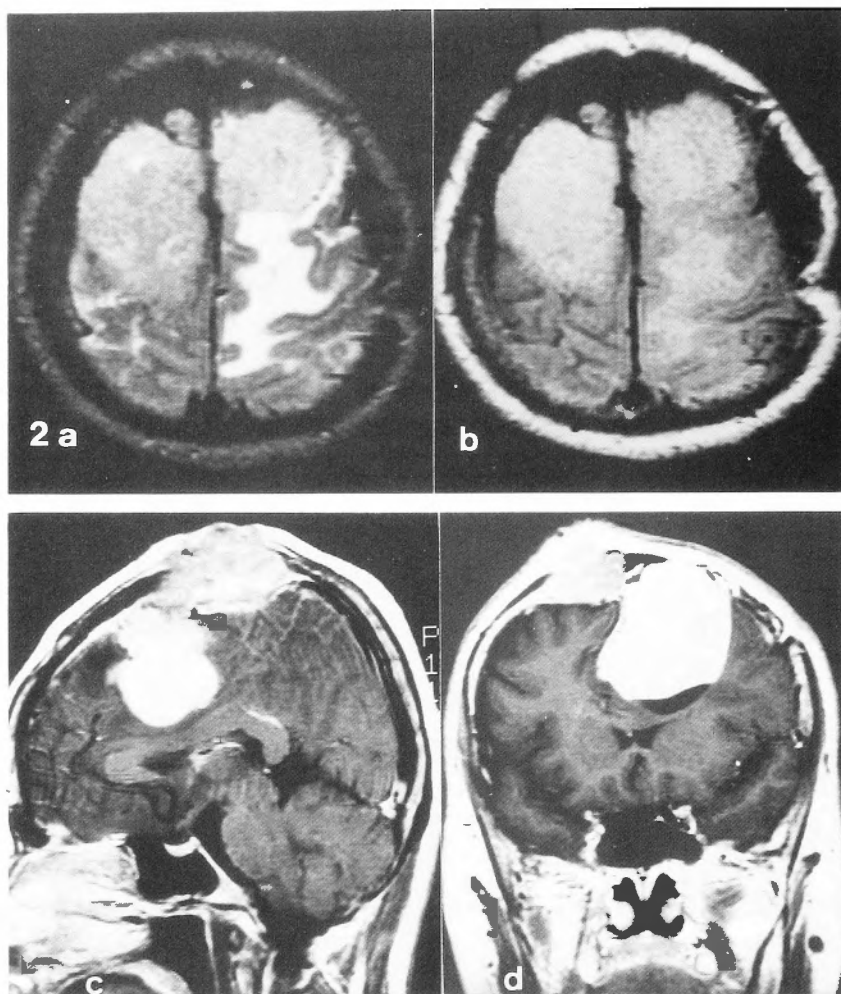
Magnetic resonance images. *a*: Axial T_2 -weighted image demonstrates two individual tumors with the same intensity in the bilateral frontal areas. *b*: Axial proton density-weighted image shows the couple of tumors with the almost equivalent intensities. *c*: Sagittal T_1 -weighted image with Gd-DTPA enhancement. The right intradiploic mass enhanced less than the left parasagittal tumor. *d*: Coronal T_1 -weighted image with Gd-DTPA enhancement. The two tumors seem to have connection on the midline.
